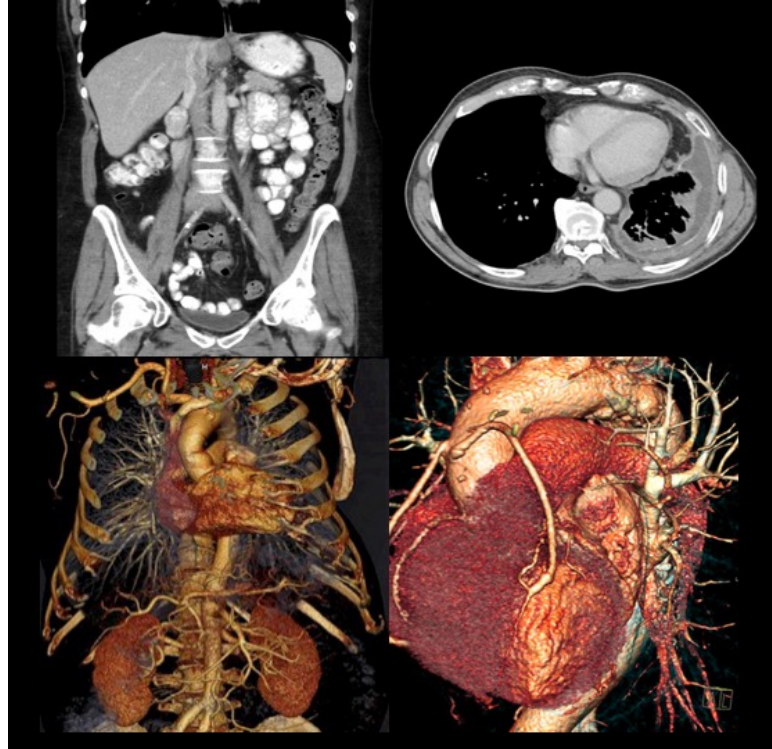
A CT scan of the chest and abdomen. At the bottom, the two images are a 3D rendering and the other pictures are cross-sectional slices through the 3D image. Note that the principle is the same as X-ray imaging, but with more detailed information.
